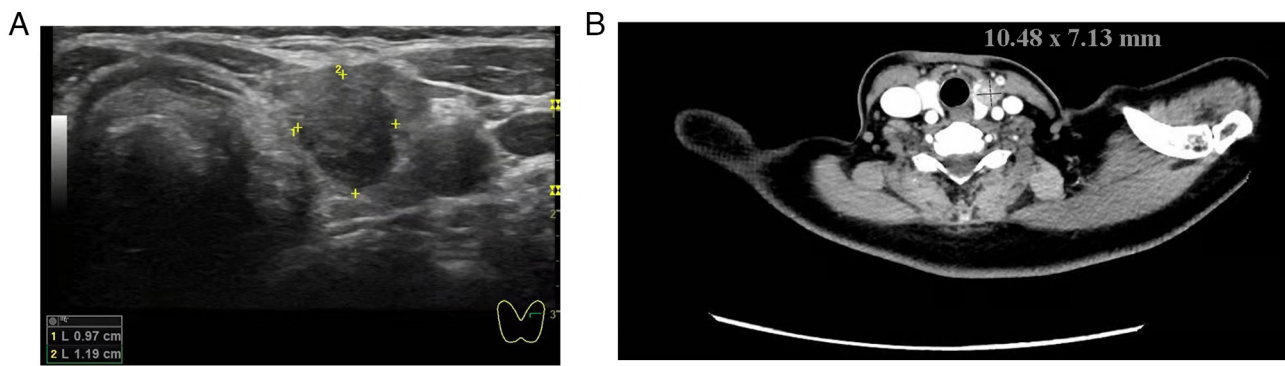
Ultrasonography and CT images of the thyroid nodule. (A) Ultrasonography revealed a hyperechoic nodule in the left lobe of the thyroid gland. (B) CT images demonstrated a solid nodule in the left lobe of the thyroid gland. CT, computed tomography.
